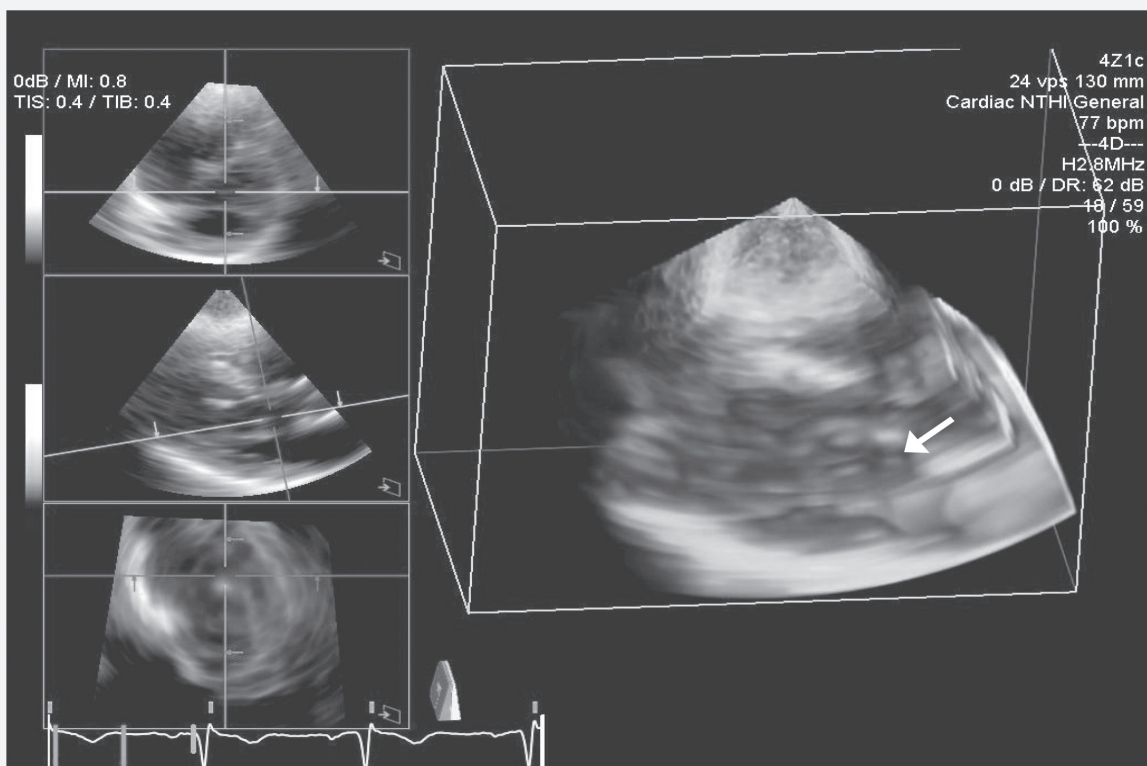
Transthoracic 3D echocardiography en-face view of the anteriorly located mitral valve orifice (1) from an LV outflow tract perspective. This image demonstrates how the said orifice opens directly into the LV outflow tract, as opposed to the more posterior orifice, which opens into the LV cavity. Abbreviations: 3D, three-dimensional; LV, left ventricular.
